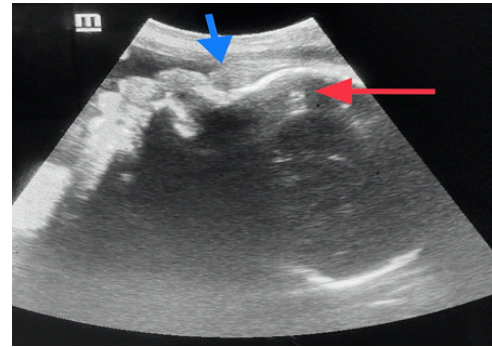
Ultrasound image of a sagittal slice of the fetal brain showing:
